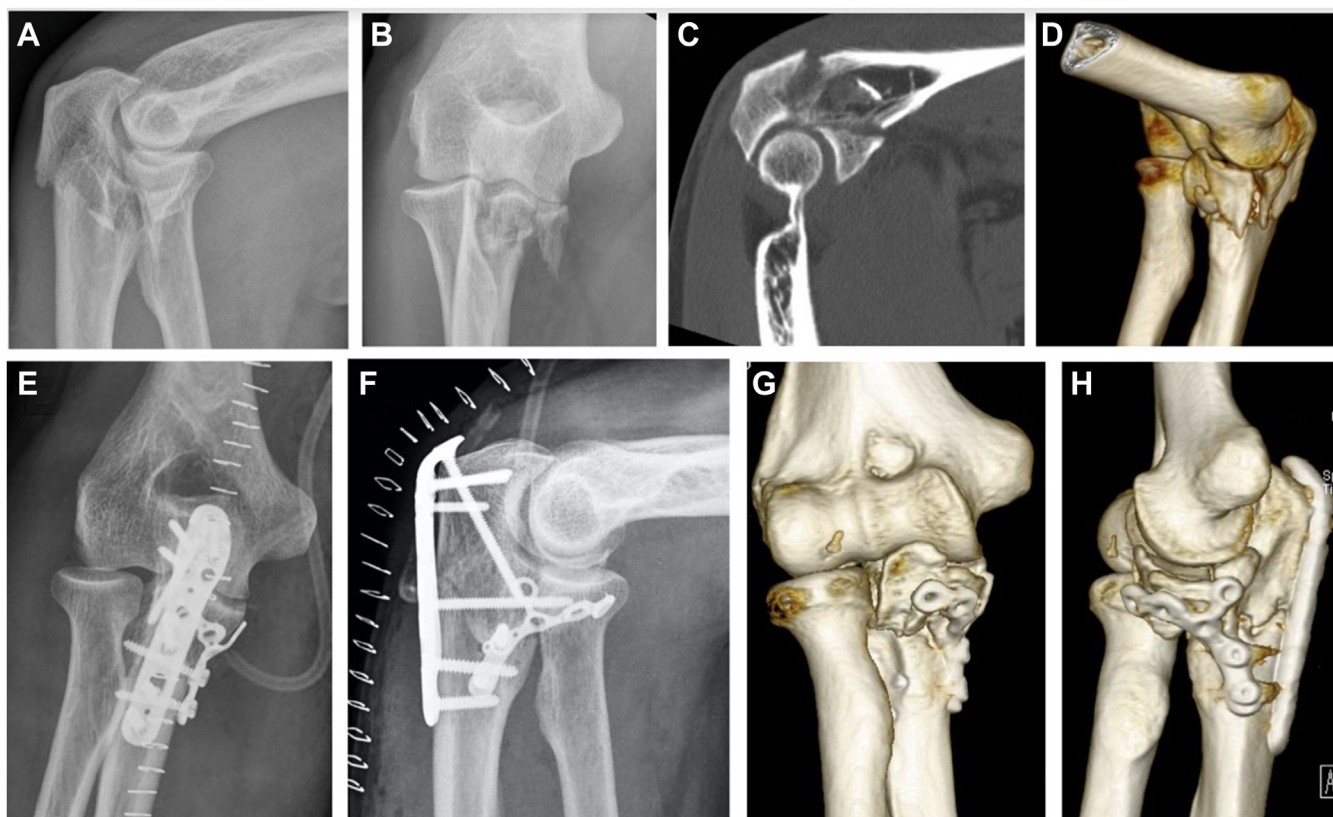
Case 9 TOFD with a basal subtype 2 coronoid fracture treated with olecranon and coronoid anatomic plates. (A–D) preoperative after reduction left elbow fracture-dislocations (A) AP view X-ray, (B) lateral view X-ray, (C) CT scan 2D sagittal view, (D) CT scan 3D reconstruction. (E and F) postoperative X-ray (E) AP view, (F) lateral view. (G and H) 3D reconstruction of the 3rd month CT scan, advance healing process. AP, anteroposterior; CT, computed tomography; TOFD, transolecranon fracture-dislocation.
